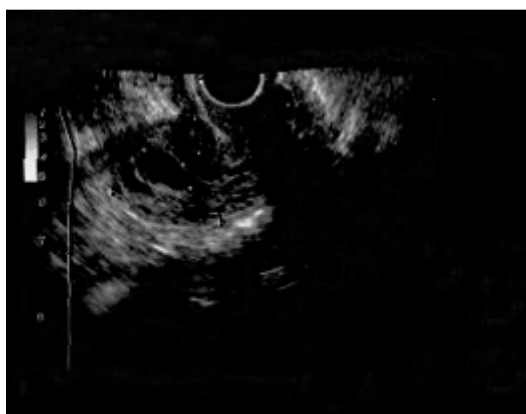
Ultrasonography demonstrated lobulated uterine enlargement, with focal anechoic area.
